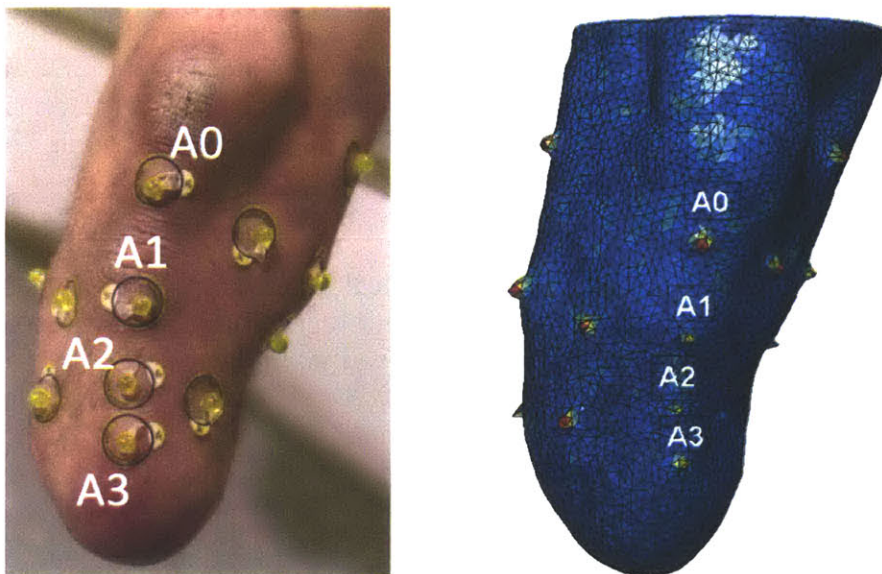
MRI markers placed on the actual skin surface (left) and the corresponding marker regions highlighted on a surface model derived from the MRI data (right). A distance metric is used to quantitatively identify marker locations in the model (red locations corresponds to largest differences between the surface with a marker and the surface without, that is, marker locations)
